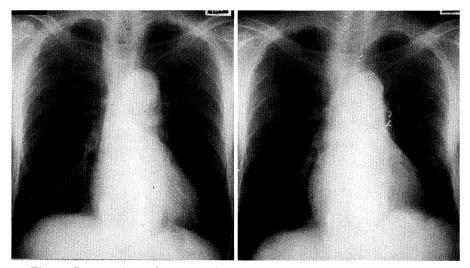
Preoperative and postoperative (12 months after sleeve segmentectomy of the left lingula) chest x-ray films of a 74-year-old man.
